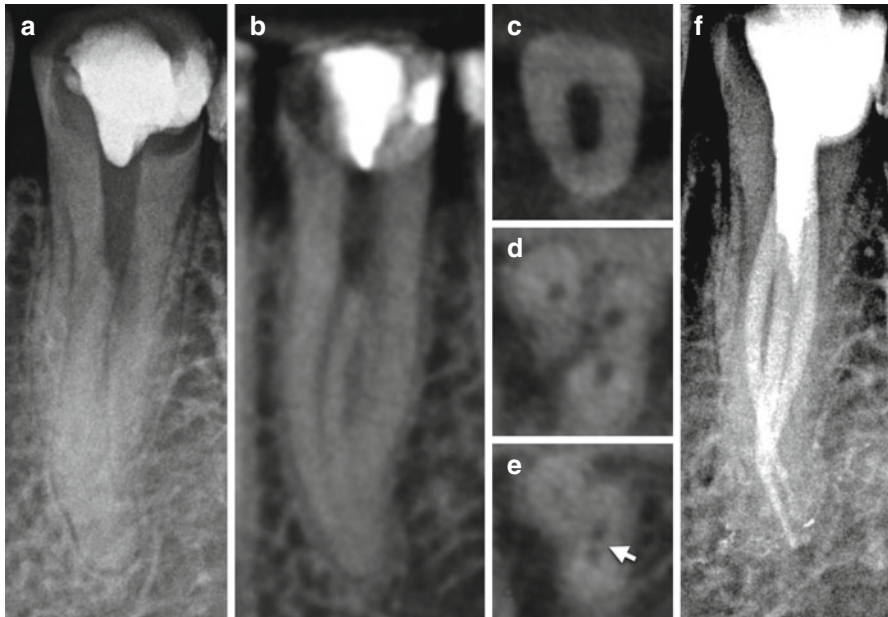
Preoperative periapical radiograph of a previously accessed right mandibular second premolar demonstrating a classic "fast break" (a). The sagittal CBCT slice demonstrates a division of the buccal roots at the level of the "fast break." (b) The axial CBCT slice captured from the coronal third (c), mid-root (d), and apical third (e) demonstrates one root canal system trifurcating into three separate canals with confluence of the distobuccal and lingual canals in the apical third (arrow). Post-endodontic periapical radiograph demonstrates all identified root canal systems treated (f)
